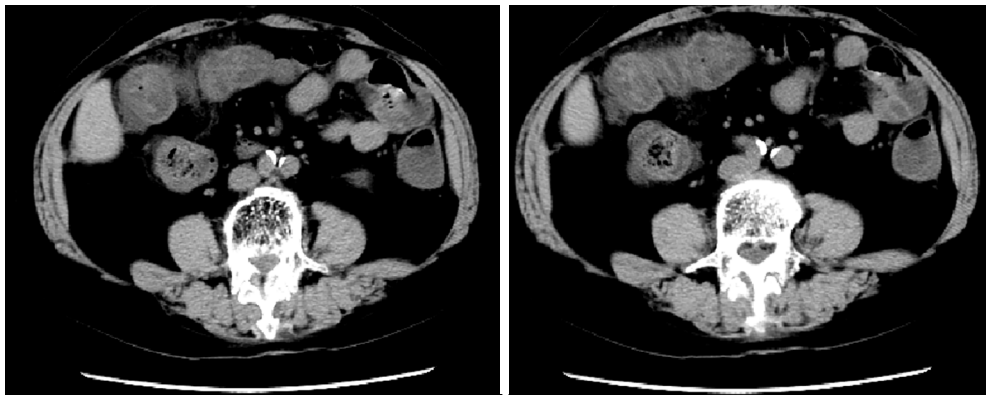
Abdominal CT scan. The hepatic flexure and transverse colon were thickened and densified; the serosal surface was rough, and the fat was exudated. CT, computed tomography.
